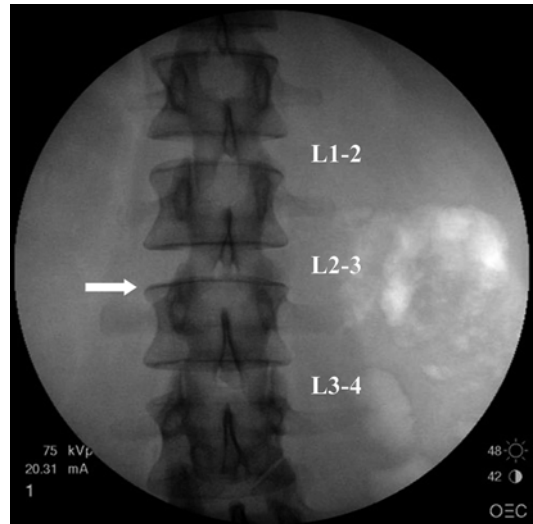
AP view of the lumbar spine. Target disk is at L2–L3. Closed white arrow indicates superior end plate of L3 parallel to the X-ray beam
